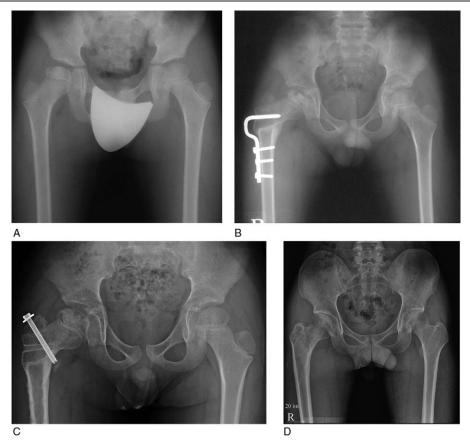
(A) Anteroposterior radiograph of the lateral pillar classification in a patient who was 7.1 years old at presentation. (B) Postoperative anteroposterior pelvic radiograph after GTE and 6 months after FVO. The ATD was 6.5 mm for the affected hip and 38.5 mm for the normal hip. The CTD was -8.1 mm for the affected hip and 26.5 mm for the normal hip. The NSA was 113.5° for the affected hip and 146.1° for the normal hip. (D) Anteroposterior radiographs at skeletal maturity showing correction of trochanteric overgrowth of the right hip. The ATD was 15.8 mm for the affected hip and 18.2 mm for the normal hip. The CTD was -3.4 mm for the affected hip and 1.5 mm for the normal hip. The NSA was 128.5° for the affected hip and 138.3° for the unaffected hip.
